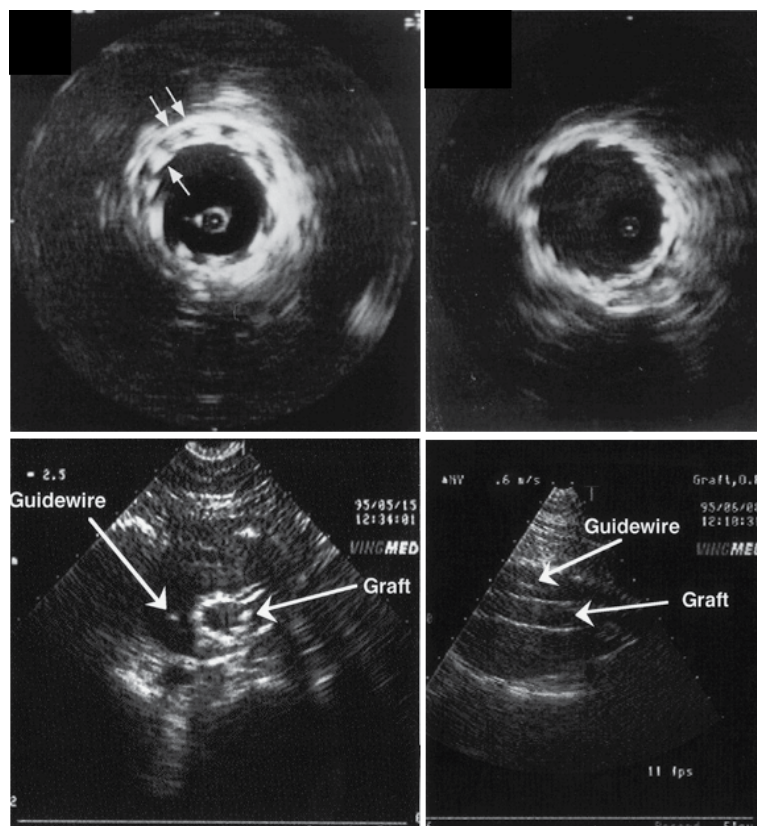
Upper: IVUS during EVAR, left: incomplete stent expansion, right: stent correctly placed after additional dilation. *In White et al. (1995), used with permission.* Lower: Transabdominal ultrasound guidance during EVAR. Guidewire and stentgraft is visible inside the aneurysm. *In Lie et al. (1997), used with permission.*
